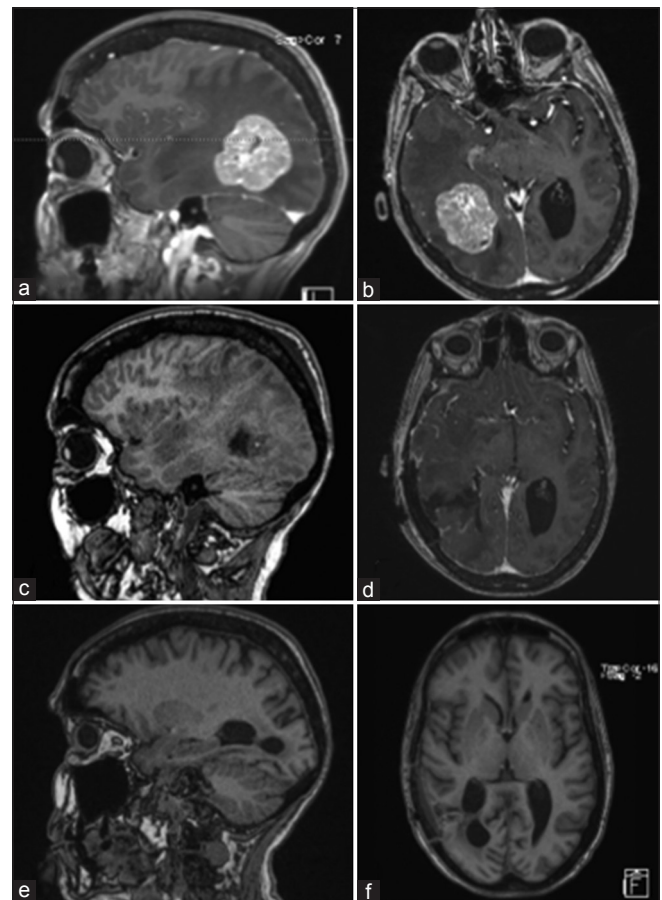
Pre-operative MRI of brain showing a solitary heterogeneously enhancing solid mass at the right temporal-parietal junction with surrounding edema, mass effect, and early uncus herniation (a and b). Immediate post-operative MRI of brain showing post-operative changes in right temporal-parietal area with gross total resection of the lesion (c and d). MRI of brain seven weeks after surgical resection showing no evidence of tumor progression, significantly improved edema around the resection area, and partially entrapped right occipital horn likely from intraventricular adhesive disease (e and f)
